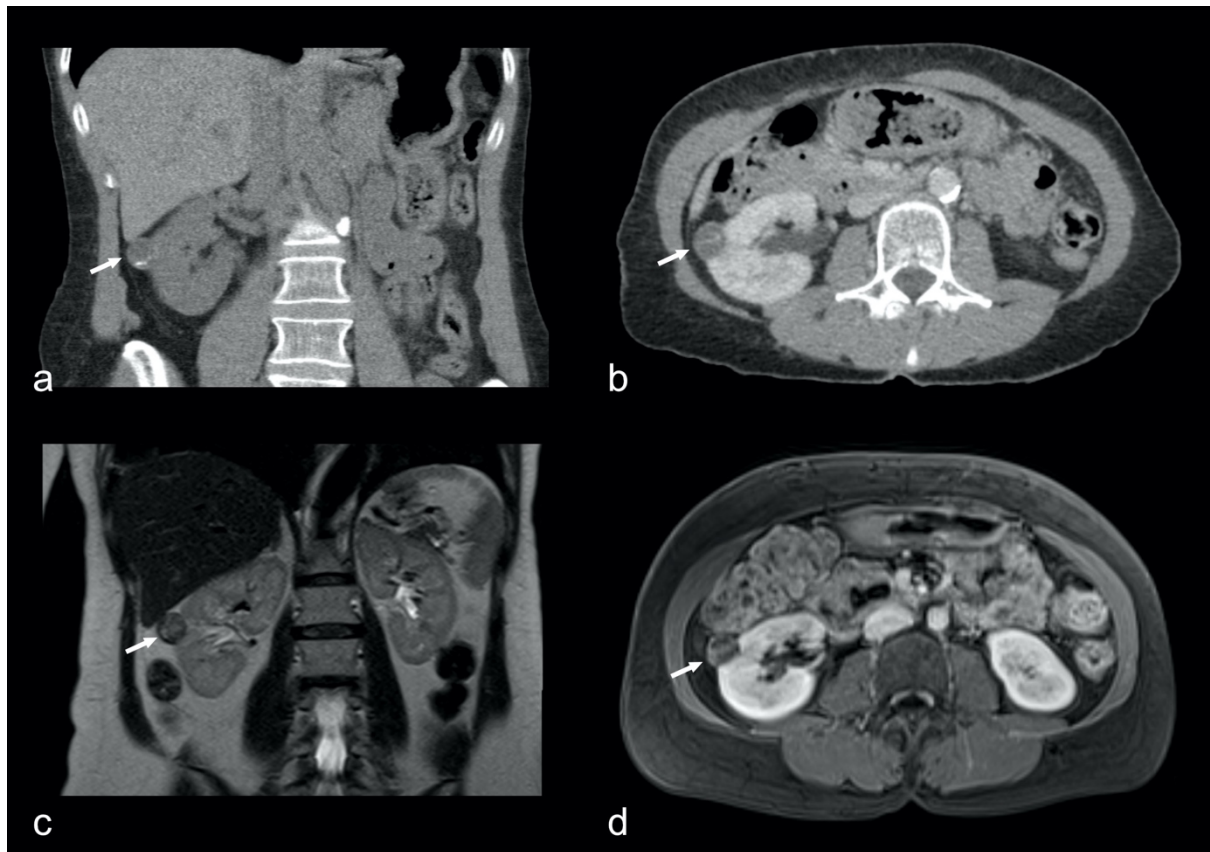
RCC of papillary subtype (arrow) with small calcifications (a) on the native coronal CT scan. The nephrographic phase reveals enhancement of septa (b, d) on the axial CT scan and the T1 weighted MRI axial MRI sequence, respectively. T2 weighted coronal MRI sequence of the upper abdomen (c) in the same patient reveals the non-cystic nature of the renal tumour. (*Karolinska University Hospital Huddinge, MIDOR study*)
